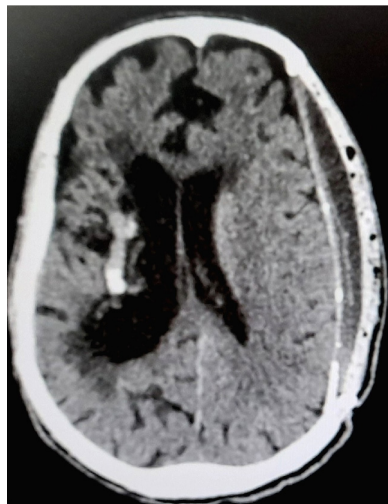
Postoperative CT with EAFC (+)
